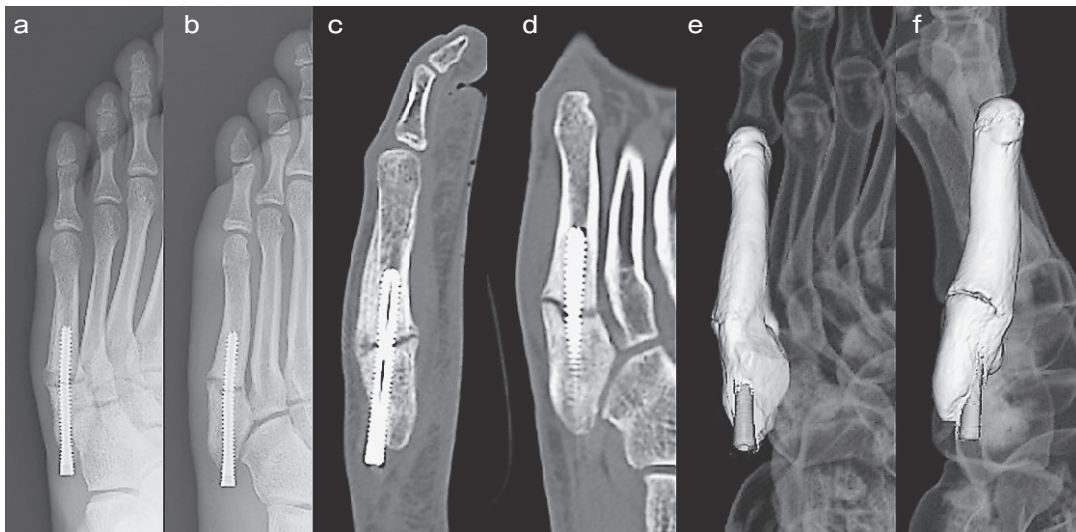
Left foot X-ray and CT, re-fracture associated with screw breakage
